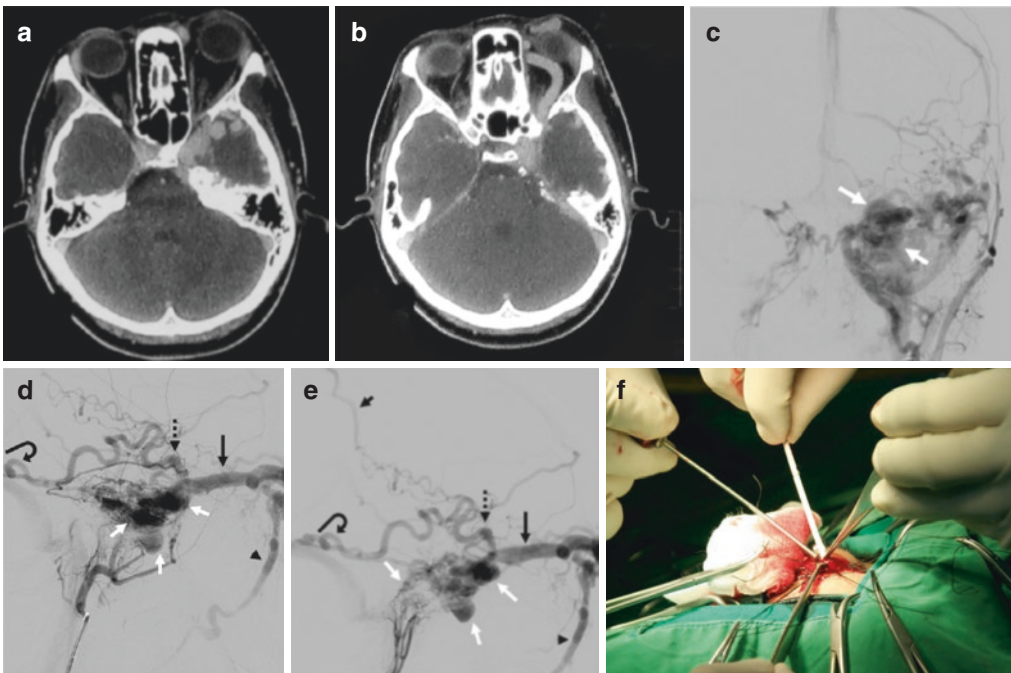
Direct SOV puncture. (a, b) Axial contrasted CT of a 20-year-old female who presented with left eye proptosis and bruit without a history of trauma revealing enlarged left CS, dilated left SOV, and SMCV. (c–e) Left ECA angiogram showing huge left dCCF (white arrow) supplied from all meningeal arteries, especially the ascending pharyngeal branches with drainage to the left SOV (black arrow) and significant cortical reflux from the SMCV (dashed arrow) to Labbe’s vein (curve arrow) and Trolard vein (short black arrow, arrowhead = facial vein). Note no demonstrable IPS. (f, g) Decision was made to puncture directly into the left SOV using a 5F introducer sheath. (h, i) Coil embolization
